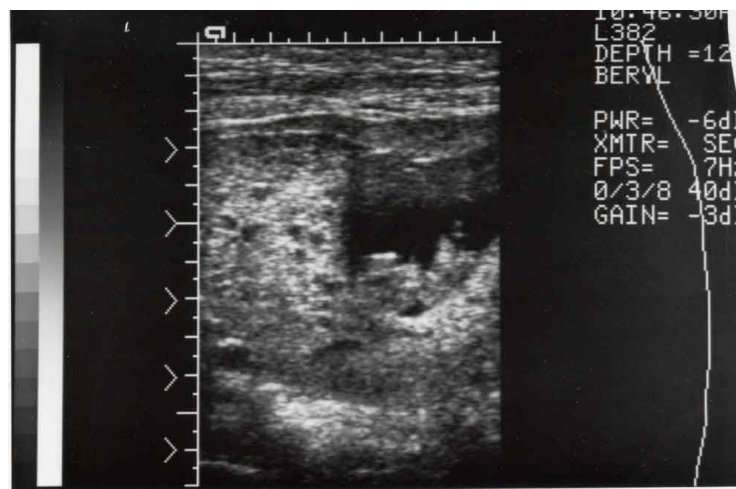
Ultrasound of a partial molar pregnancy showing a fetus and focal cystic spaces in the placenta
